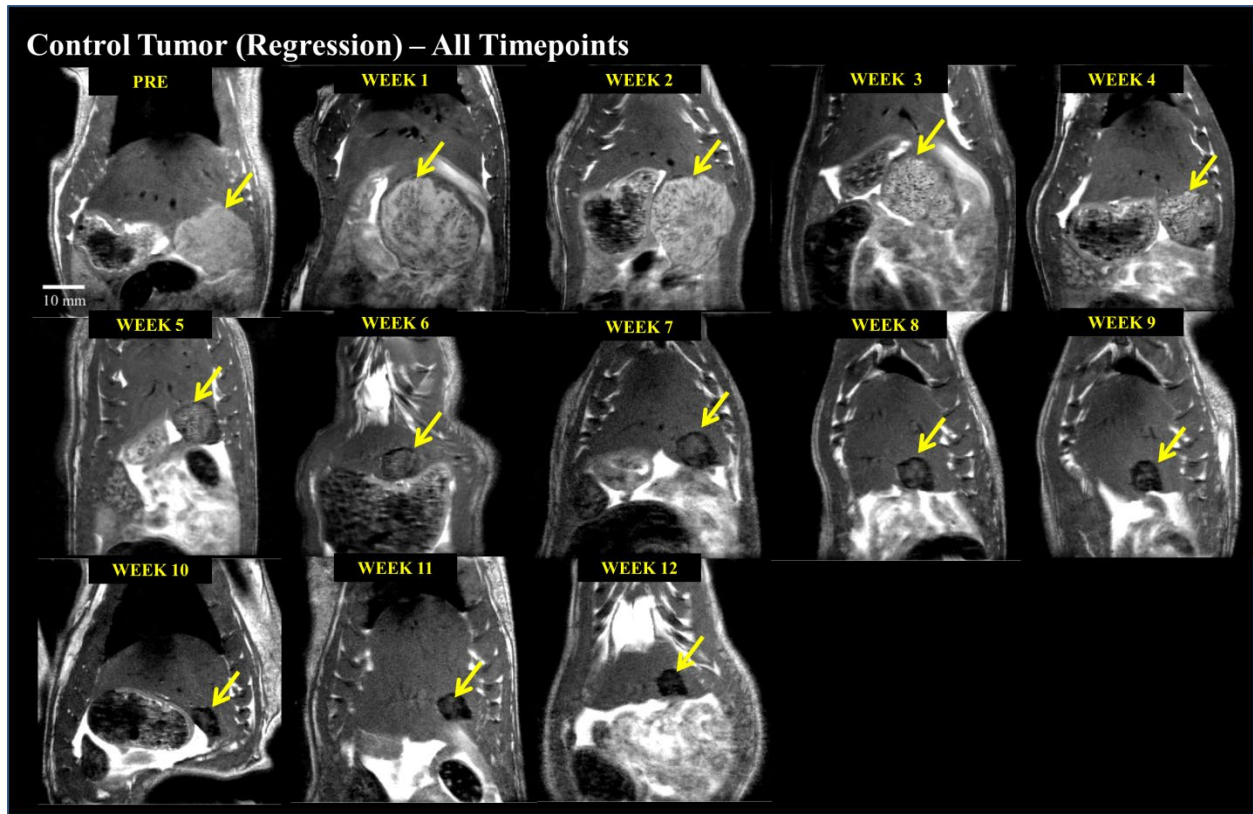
T2W MRI appearance of control tumor at all timepoints. Control tumor (yellow arrow) develops a mottled and heterogeneous appearance, similar to that of pseudoprogression by week 3, and begins to regress as evidenced by decreasing tumor burden until week 12. By week 7, the appearance of the tumor becomes hypointense and this appearance is maintained until week 12. This figure demonstrates all imaging timepoints for the case demonstrated in Figure 4-5.
